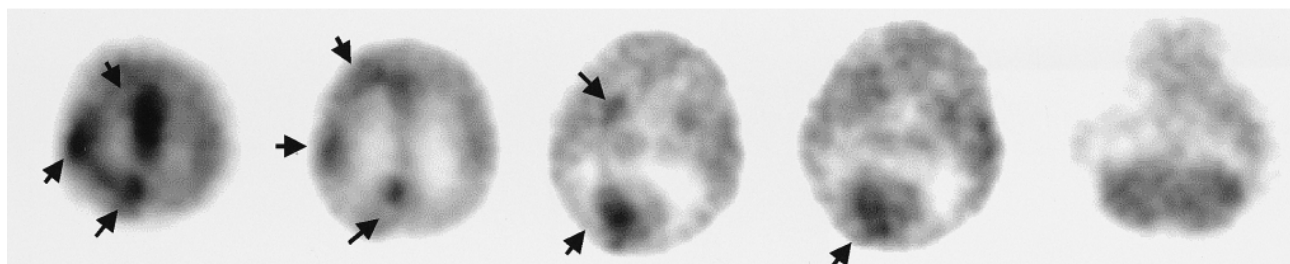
71-year-old man with post-traumatic epilepsy. Dedicated ring-detector PET images (*upper panel*) show multiple lesions of increased FDG accumulation in the right cerebral cortices and basal ganglia. Dual-head coincidence gamma camera images (*lower panel*) also show multiple lesions of increased FDG accumulation.
